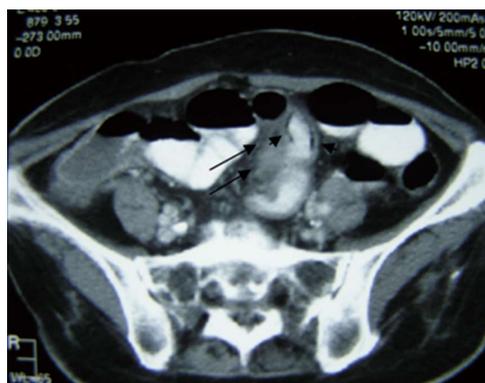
Axial contrast enhanced computed tomography demonstrates a homogeneous thickened soft tissue mass at the small bowel mesentery (long black arrows), as well as intestinal pneumatosis (small black arrows).
